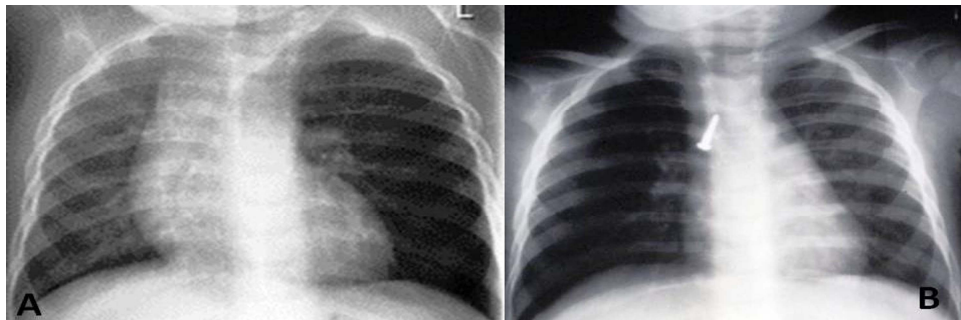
Plain X-ray chest antero-posterior view showing hyperlucency of left lung (indirect evidence of radiolucent foreign body in left main bronchus).
